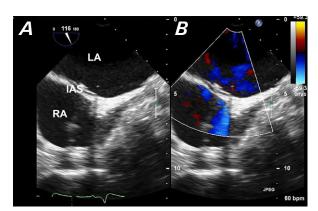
Transesophageal echocardiograms (bicaval view) show A) no communication and B) no color flow between the superior vena cava and right atrium (RA).
